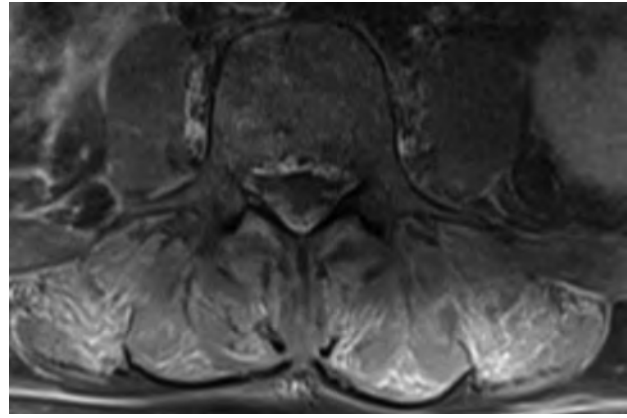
Same 56-year-old man with COVID-19 seen in Fig 1. Axial post-contrast, fat-saturated T1-weighted image of the lumbar spine demonstrates symmetric areas of intramuscular enhancement involving the erector spinae and multifidus muscles bilaterally.
